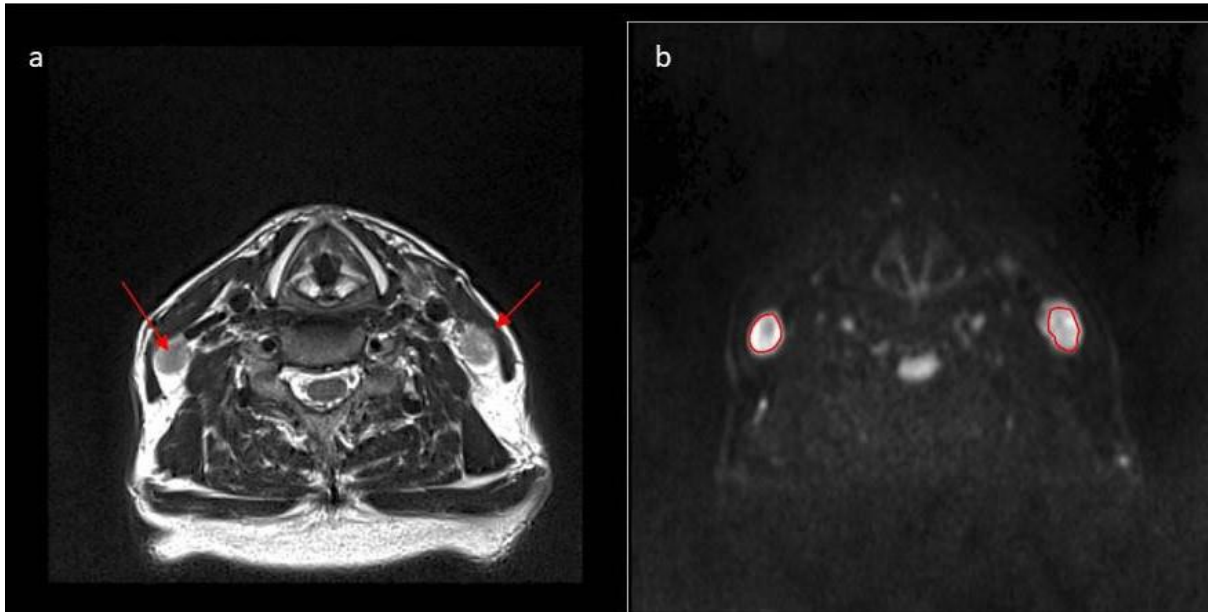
(a) Axial Periodically Rotated Overlapping Parallel Lines with Enhanced Reconstruction (PROPELLER) T2-weighted image demonstrating two diseased nodes, arrows denoted the diseased nodes) in 56-year old man. (b) Axial diffusion weighted trace (DW) image ($b=300 \text{ s/mm}^2$) with the contoured regions of interest in 56-year old man.
